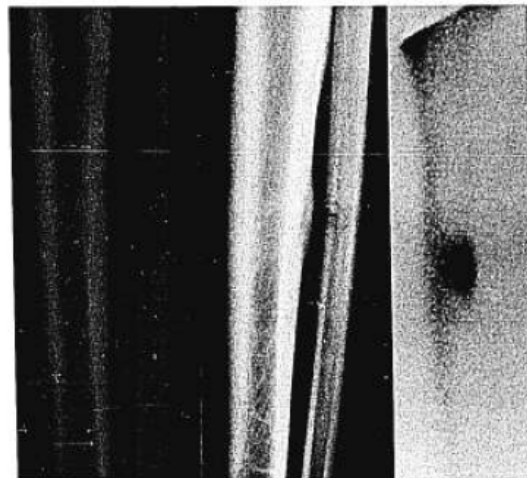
(Patient 25) (Left) Lateral roentgenogram of right tibia shows no fracture. (Center) Same view two months later shows stress fracture of posterior mid-shaft. (Right) Scintiscan of lower leg shows localized area of increased tracer activity at stress fracture site.
